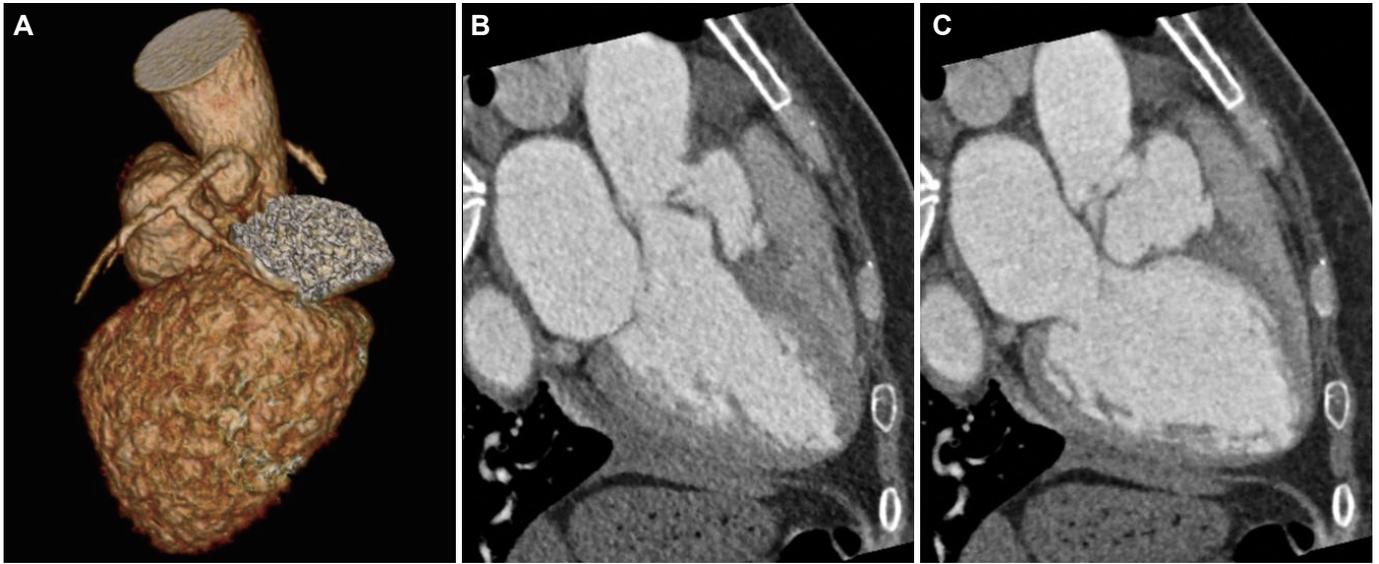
MDCT findings. A: left lateral view of reconstructed image well visualizes the right SVA. B: MDCT shows interventricular dissection which forms cystic cavity at diastole. C: the interventricular cavity increases in size during diastole. MDCT: multi-detector computed tomography, SVA: sinus of Valsalva aneurysm.
